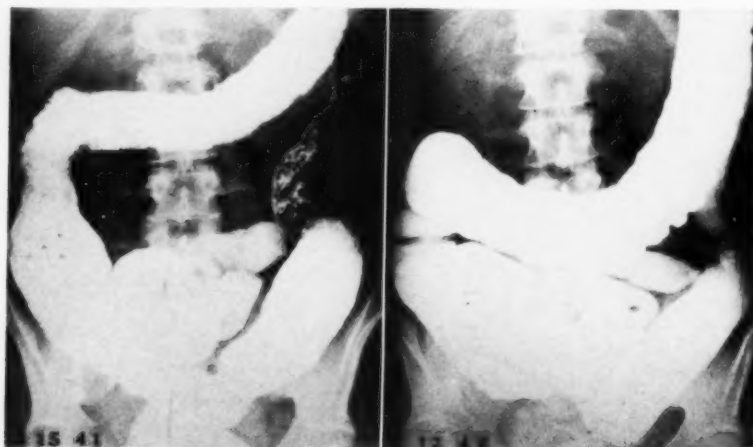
L. M. G. Improvement in roentgen appearance of colon. Complete clinical recovery.
